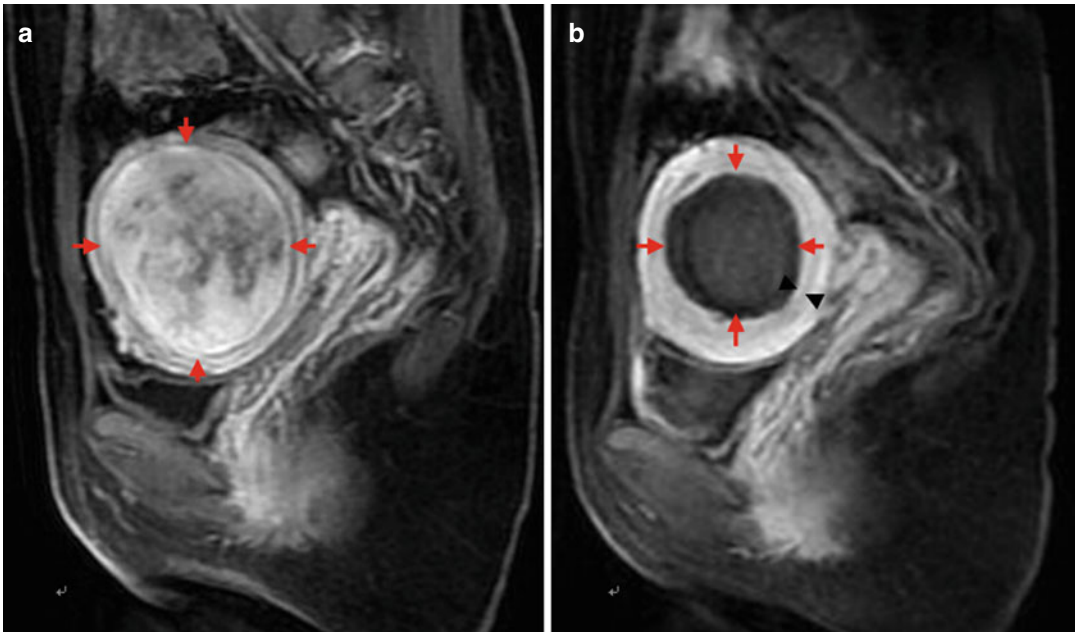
Percutaneous MWA in a 39-year-old woman with an intramural fibroid who suffered from menorrhagia and refused surgical treatment. MWA was implemented to relieve her symptom. (a) Preablation sagittal T1W1 contrast-enhanced magnetic resonance imaging (ce-MRI)
